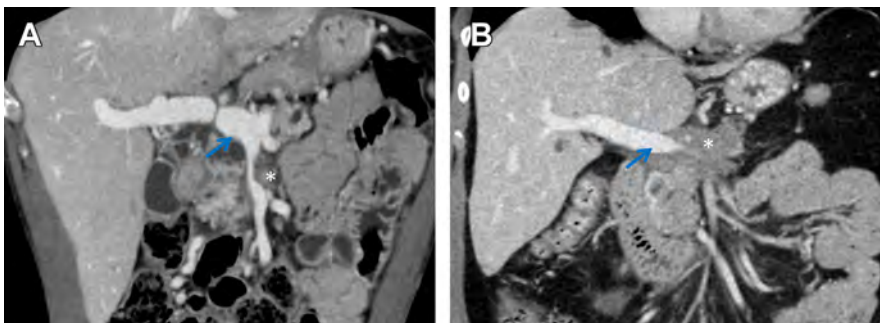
Computed tomography coronal images representing encasement of the SMV and SMV-PV confluence. (A) Greater than 50% narrowing of the SMV-PV confluence (*arrow*) with a distal vein suitable for reconstruction. (B) Greater than 50% narrowing of the SMV-PV confluence, however without a distal vein that is suitable for reconstruction. Tumor is marked by *asterisk*.
